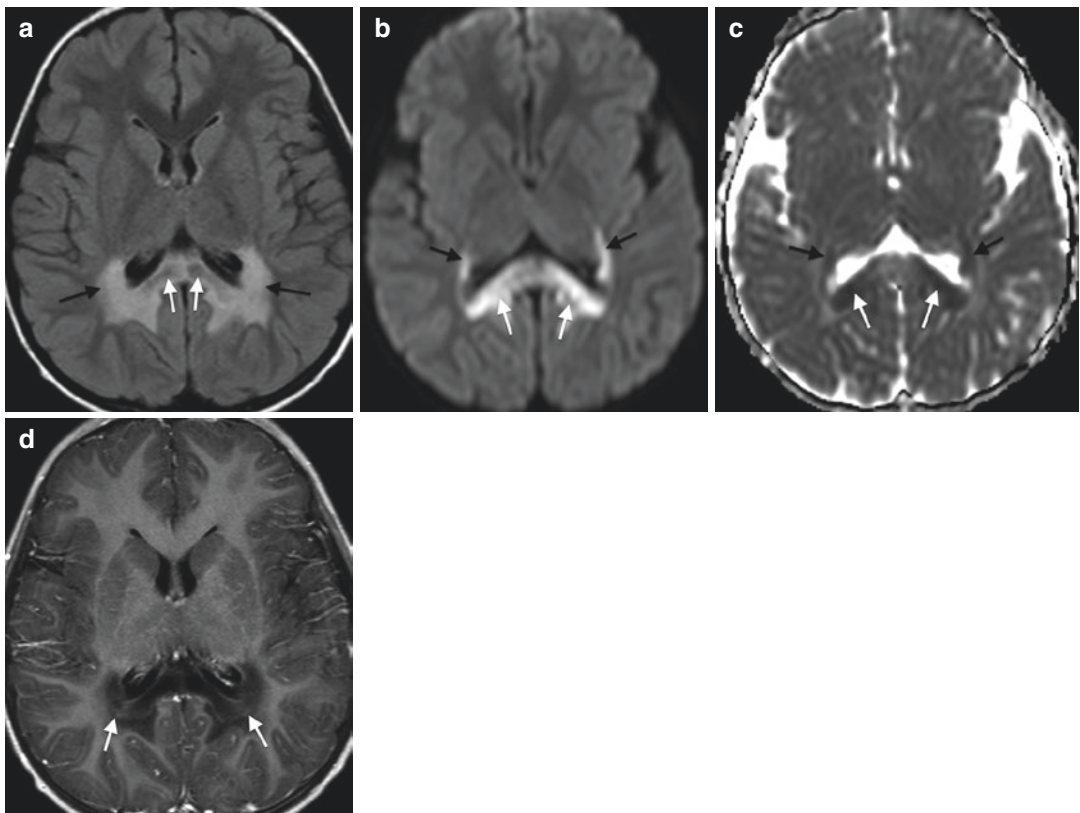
7-year-old male with X-linked adrenoleukodystrophy. Axial T2 FLAIR (TR/TE/IT ms, 8000/120/2250) (a), DWI (TR/TE ms, 3566/74) (b), ADC (TR/TE ms, 3566/74) (c), and post-contrast T1WI (TR/TE ms, 1902/20) (d) through the level of the lateral ventricles. The callosal splenium signal is abnormal with mixed hyperintensity and hypointensity (white arrows, a–c), representing
